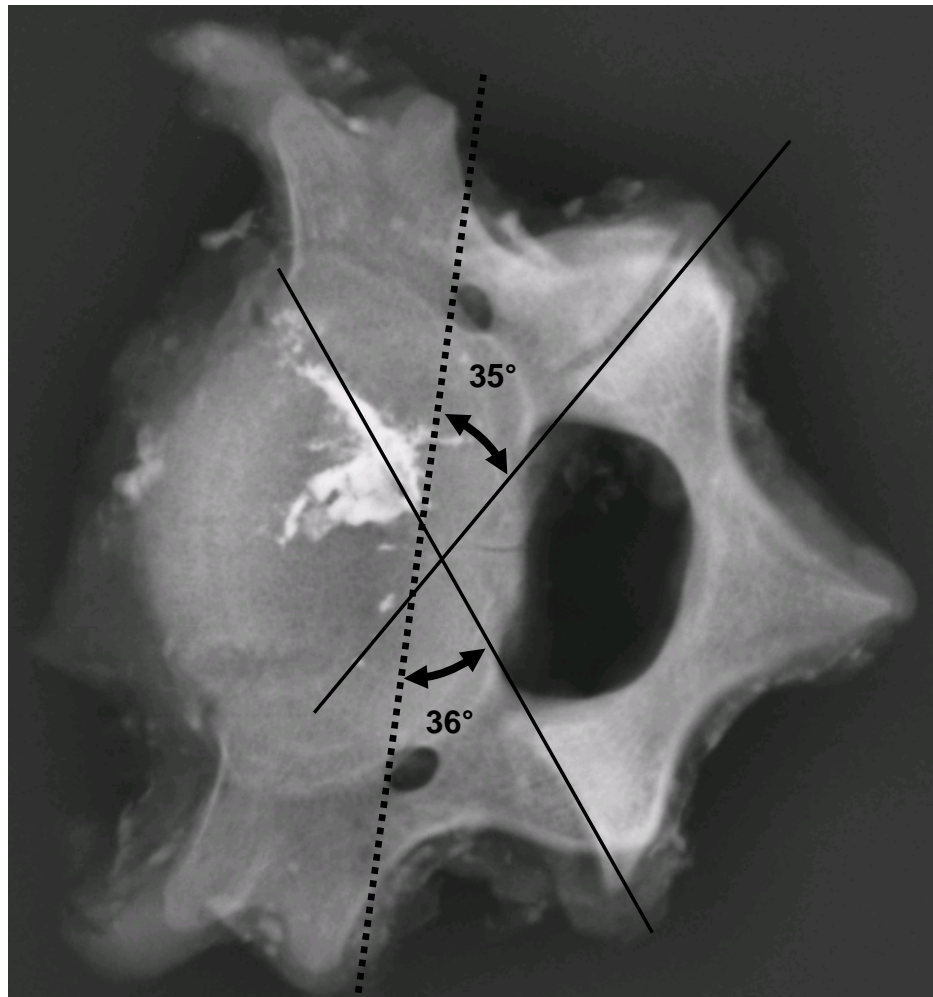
THE INDIVIDUAL FACET ANGLES WERE MEASURED FROM THE C3 X-RAY USING THE DISTINCT ANATOMICAL FEATURE OF THE TRANSVERSE PROCESSES TO IDENTIFY THE CORONAL PLANE, AND THE BISECTION OF THE SPINOUS PROCESS TO IDENTIFY THE SAGITTAL PLANE (REMOVED FOR CLARITY). THE FACET ANGLE WAS ASSIGNED BETWEEN A STRAIGHT LINE BETWEEN THE EDGES OF THE FACET AND THE CORONAL PLANE. THE FACET ANGLE DIFFERENCE (RIGHT-LEFT) WAS CALCULATED FROM THIS DATA.
